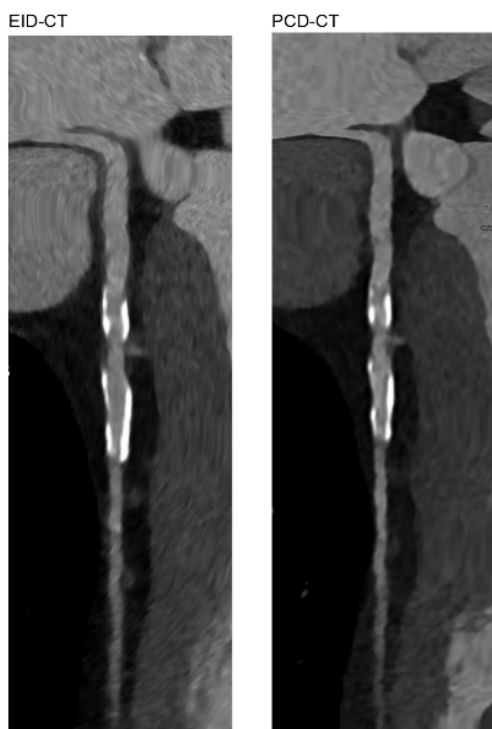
Representative image in a patient scanned with the EID- and PCD-CT
